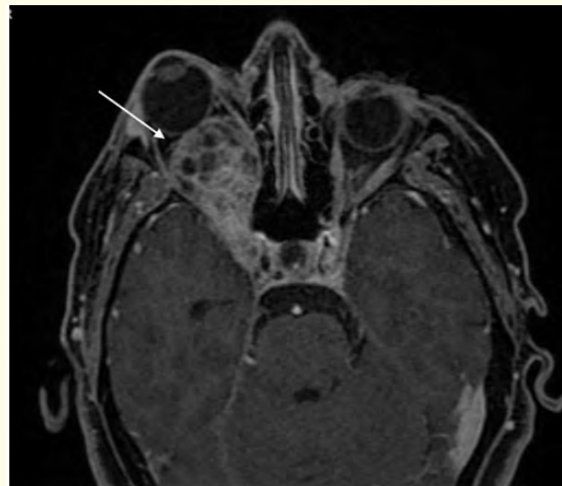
Axial post-contrast fat-suppressed T1-weighted MRI image showing intense, heterogeneous enhancement of the lesion.
